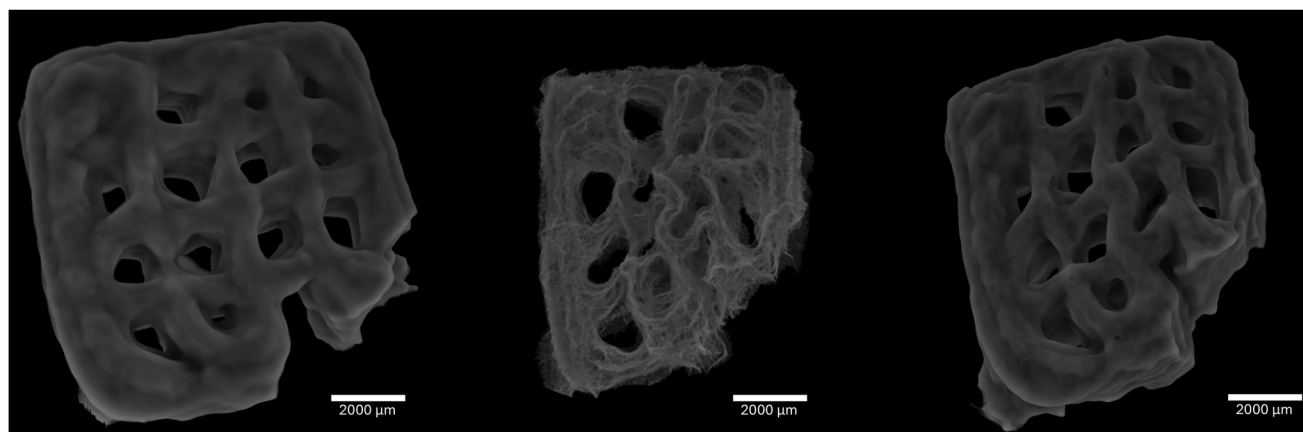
X-ray CT scans depicting the structural changes of the gel at different stages of the process: recently printed (left), post freeze-drying (middle), and after re-hydration (right). To ensure consistent orientation across the scans, one corner of the sample was deliberately removed.
